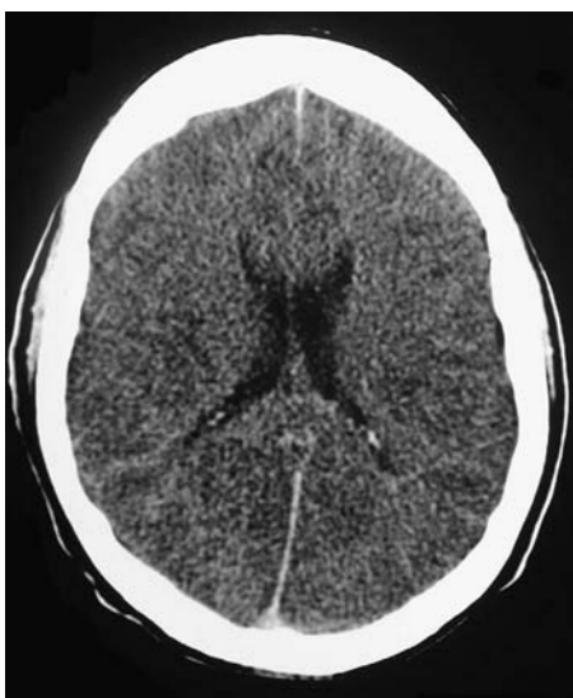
Severe secondary brain injury (non-enhanced CT). There is reversal of the normal grey–white matter pattern with low density change involving the cortex with generalized cerebral swelling indicative of hypoxic/anoxic brain injury.
